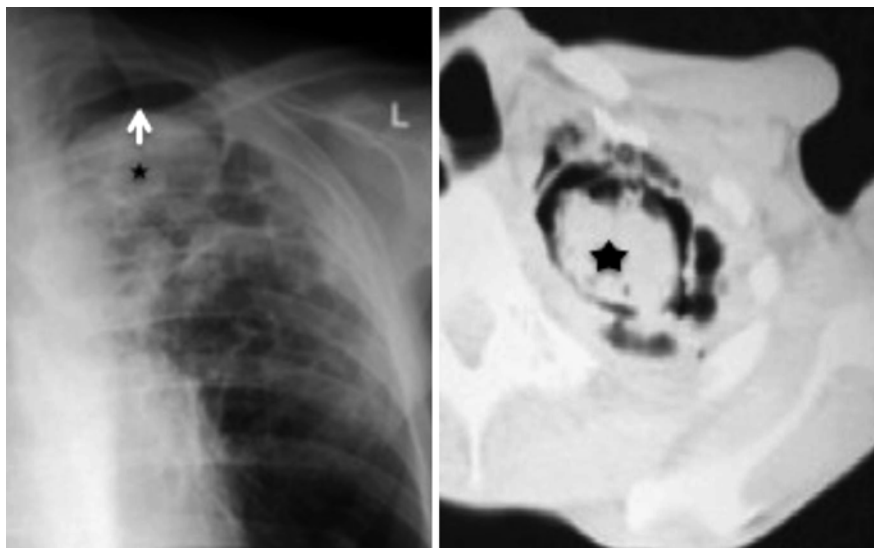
Chest radiograph shows volume loss in the left upper lobe with an apical cavity with air crescent sign (*arrow*) containing an intracavitary body (*star*) with adjacent pleural thickening. CT confirms findings typical of an aspergiloma (*star*)
